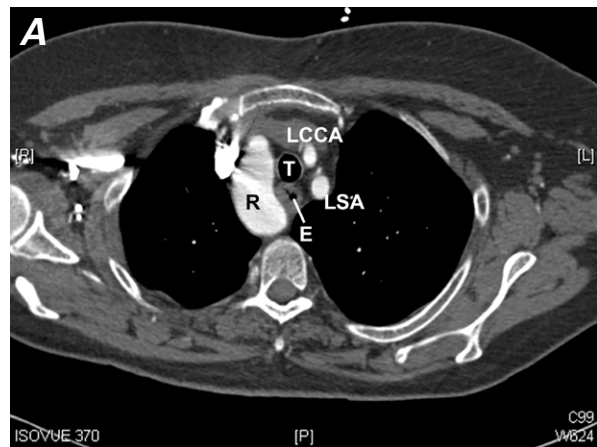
64-Slice cardiac computed tomograms (all axial views) at the levels of the A) right and B) left aortic arches and the C) aortic valve. In C, note the stent (arrow) in the right coronary artery at the level of the aortic valve. The descending aorta is right sided.
